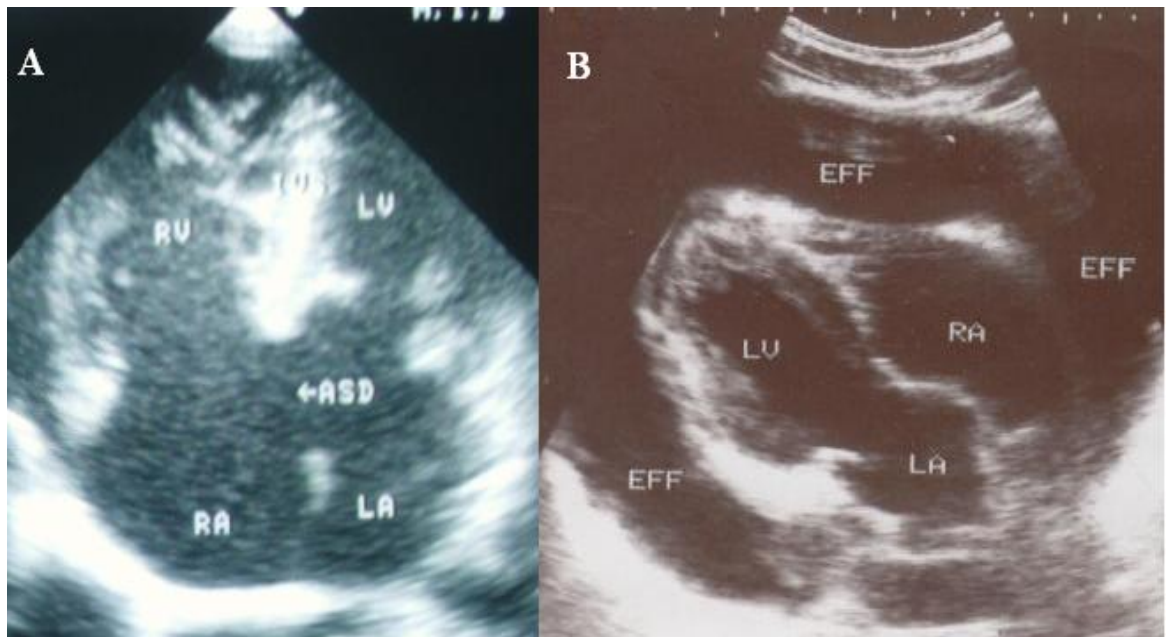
Echocardiogram of a subject with a large atrial septal defect; B. 2D echocardiogram of a subject with effusive pericarditis
